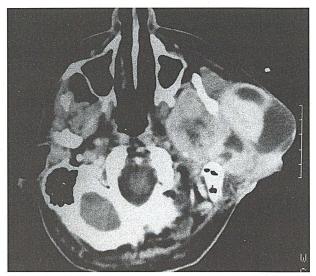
CT shows that the large recurrent tumor has invaded the left pterygopalatine fossa and the infratemporal fossa. Note the development outside the cheek.
